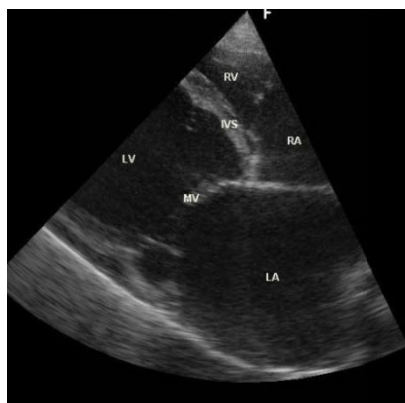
Echocardiography of the second patient: Left ventricular end diastolic dimension=55mm, Left ventricular end systolic dimension=37mm, right ventricular end diastolic dimension=30mm, left ventricular mass index=106.4 g/m².
